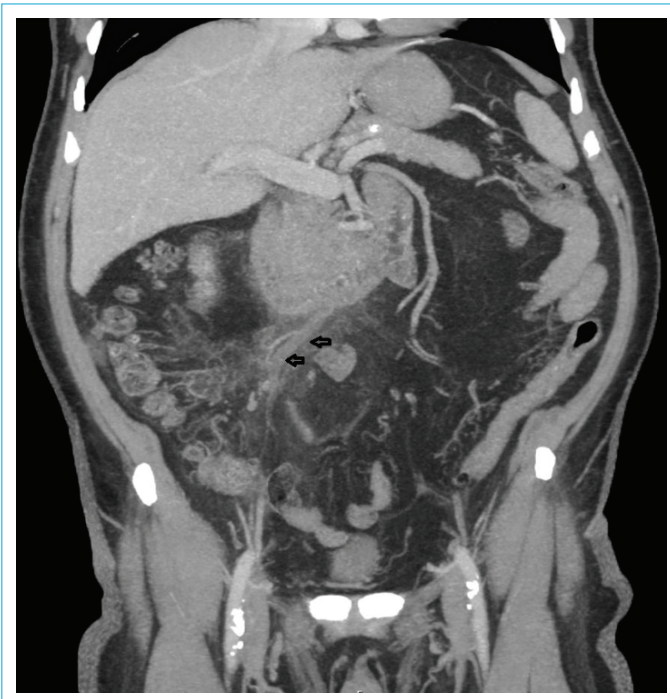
Contrast-enhanced coronal computed tomography.
